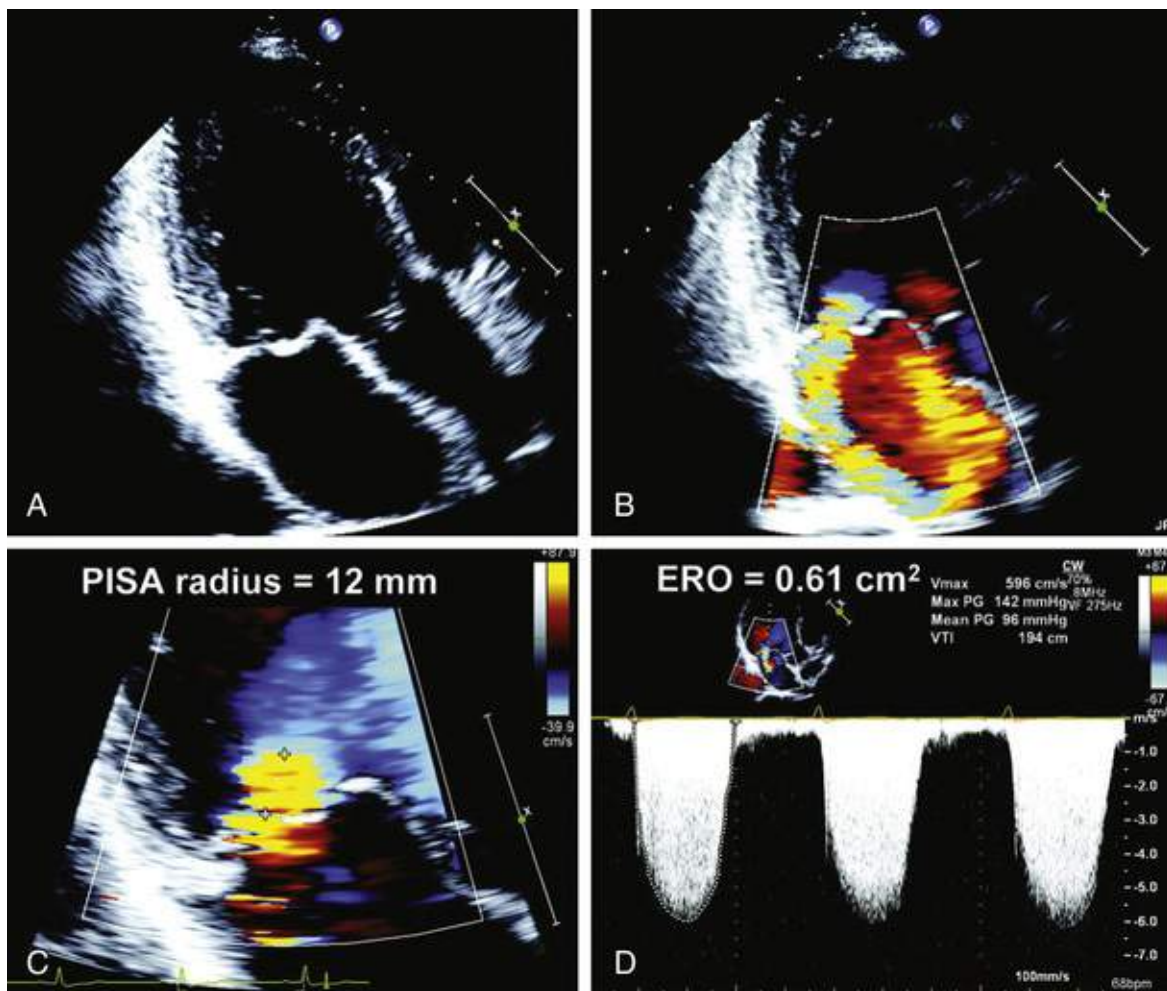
Severe mitral regurgitation caused by prolapse of the mitral valve with quantitative determination of effective regurgitant orifice area (ERO) on echocardiography. A, B, Severe prolapse of the mitral valve with severe MR. C, D, ERO was calculated with the proximal isovelocity surface area (PISA) radius and peak velocity of the MR jet. (From Kang DH, Kim JH, Rim JH, et al. Comparison of early surgery versus conventional treatment in asymptomatic severe mitral regurgitation. *Circulation* 2009;119:797-804.)
